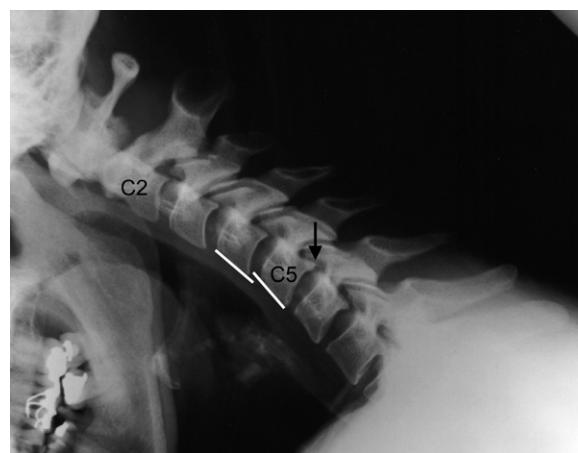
Cervical spine flexion plain X-ray image. There is some angulation at the C4–5 level where there is a loss of the normal cervical spine contour and alignment on forward bending with some anterolisthesis of C4 on C5 (measured as approximately 3 mm) suggesting a degree of instability at this level. The C5 body postero-inferior margin shows an early osteophyte developing (arrow). The anterior disc space height at the C5–6 level is less than it is at adjacent disc levels, indicating disc thinning (subsequently supported by the bulging disc at C5–6 on MRI).
